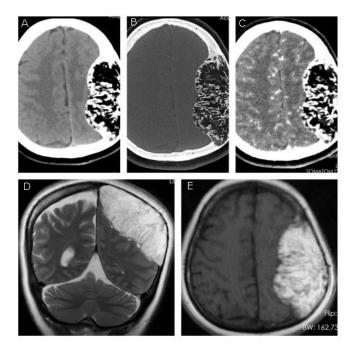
A,B,C,D,E Axial non-contrast CT images (soft tissue and bone window) show well-delineated thinned margin and typical hypodense (-80 HU) intraosseous lipoma in the left parietal bone (A, B). Enhancement is not seen in the lesion on axial contrastenhanced CT image (C). Coronal T2-weighted and axial T1-weighted MR images show typical hyperintensity of the lesion (D,E).
